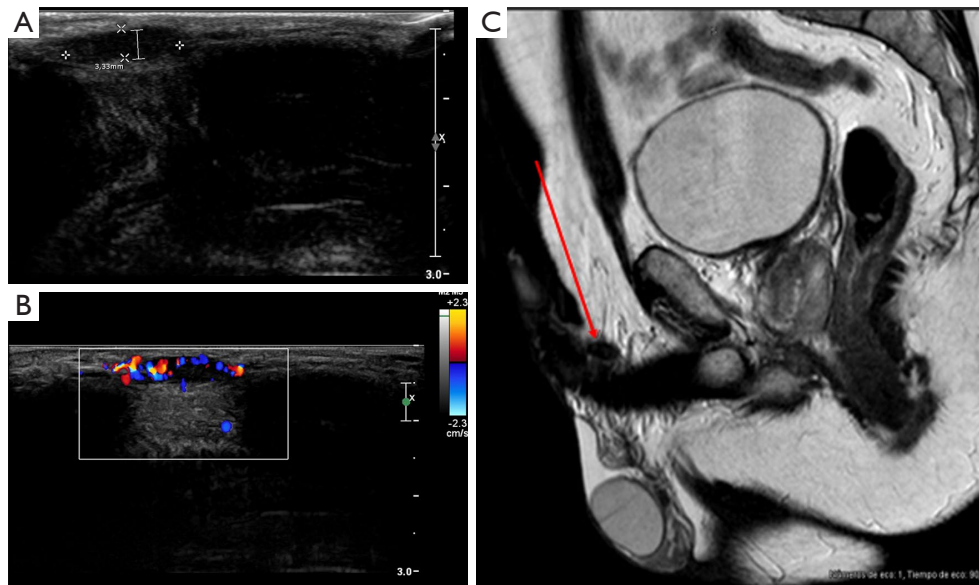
Diagnostic imaging findings on presentation. (A) A transverse ultrasound scan of the dorsal aspect of the midshaft of the penis shows the two paired corpora cavernosa a well-defined hypoechoic solid nodule, located centrally. (B) Doppler images show a hypervascular hypoechoic mass. (C) MRI T2 sagittal, revealing a small nodule (red arrow) in a corpus cavernosum, on the dorsal aspect of the penis.
